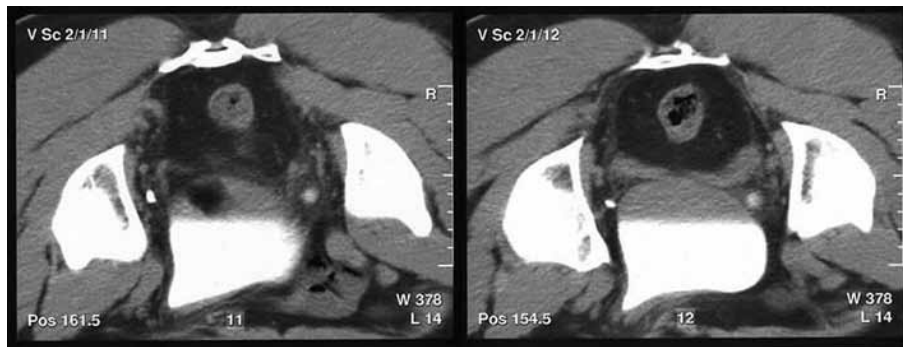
Pelvic CT scan obtained in the prone position revealed the bladder ear protruding into the inguinal canal filled with contrast media.
